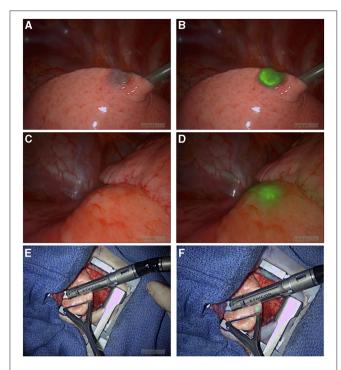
NIR-guided localization of pulmonary metastases for three thoracoscopic resections from a hepatic primary tumor. (A,B) NIR localization of a superficial nodule. This nodule was seen with both standard of care white light (A) and NIR (B). NIR, near infrared. (C,D) NIR localization of a 2 cm nodule seen on the preoperative CT scan, but not visible when seen by standard of care white light (C). (D) The same deep nodule was localized with NIR. NIR, near infrared; CT, computed tomography. (E,F) A small 0.2 cm nodule not localized with preoperative CT scan or with standard of care white light/tactile feedback (E). (F) The same nodule localized by NIR. NIR, near infrared.
